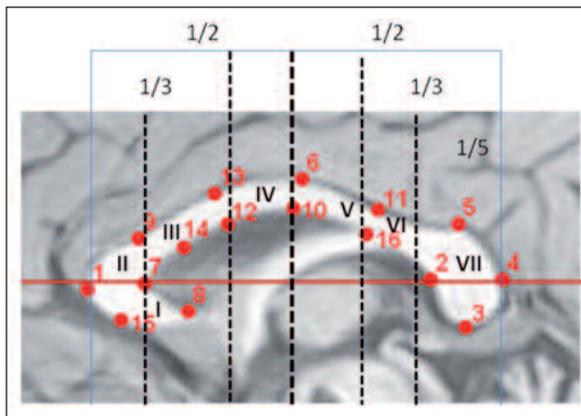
T1-weighted mid-sagittal slice demonstrating the corpus callosum landmarks and Witelson subdivisions (I: rostrum; II: genu; III: rostral body; IV: anterior midbody of corpus callosum; V: posterior midbody of corpus callosum; VI: isthmus; VII: splenium).
